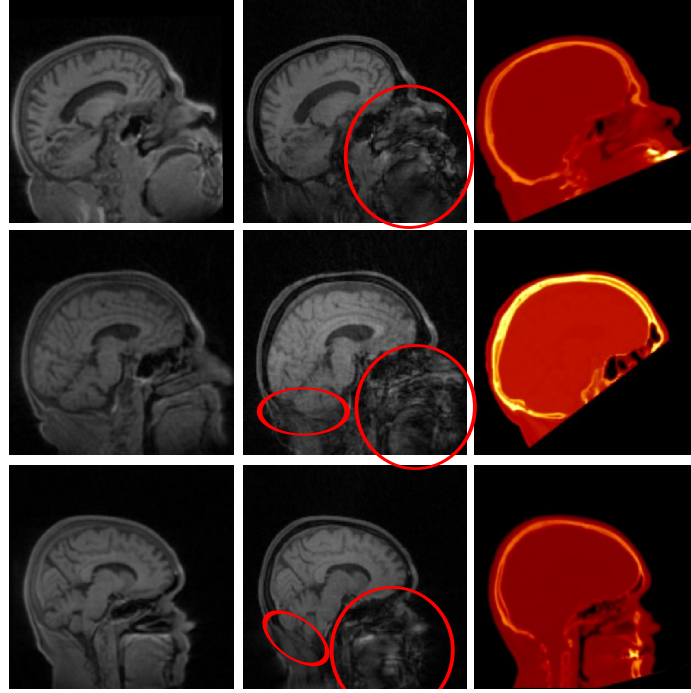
Motion artefacts for 3 different subjects. At left: UTE1 images; at the center: UTE2 images; and at right: CT images. Ellipsoids represent regions of strong motion artefacts in the UTE2 images.
